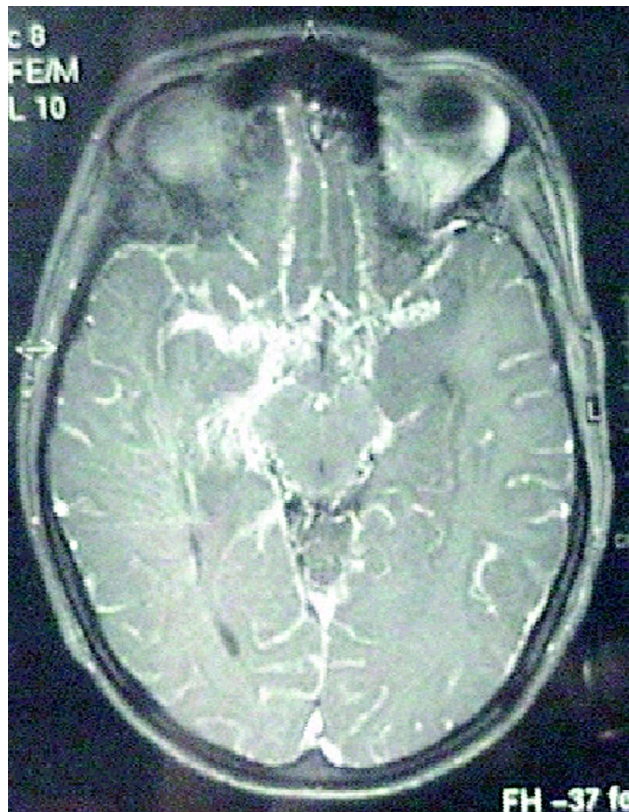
Contrast axial MRI image showing an abnormal leash of blood vessels in the circle of Willis at the base of the brain.
